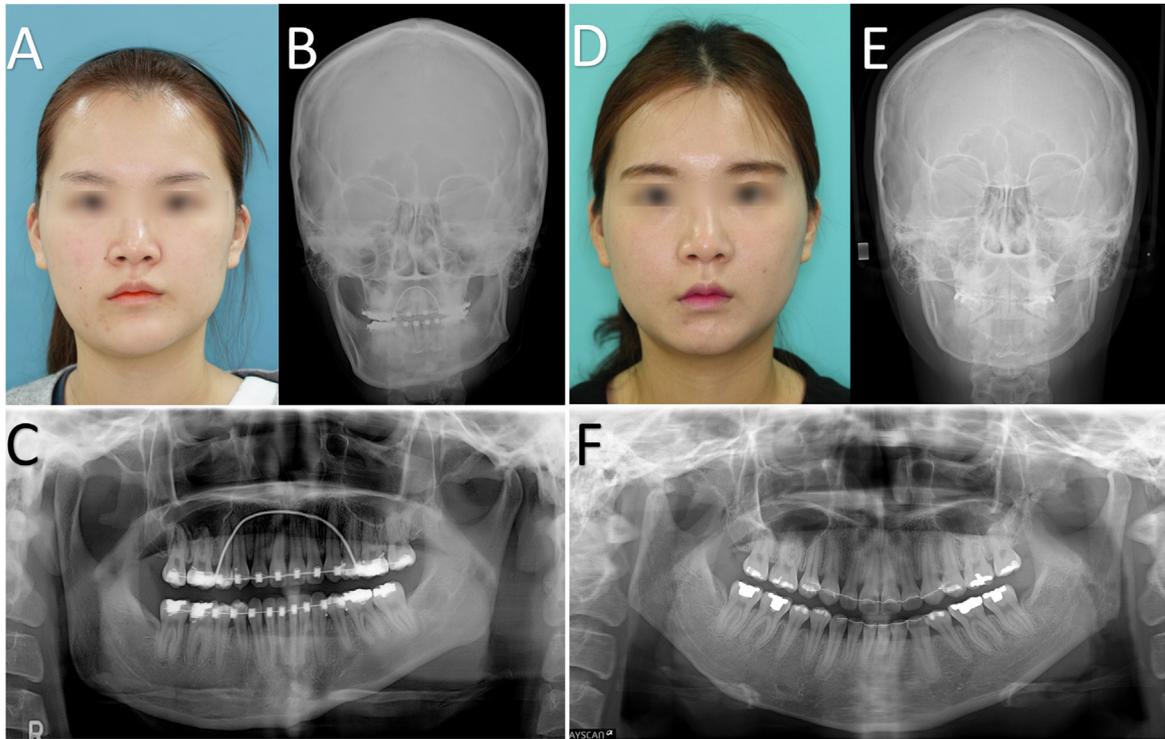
Long-term follow-up of a hemimandibular hyperplasia case (patient 18). Images obtained preoperatively: (A) frontal photograph, (B) posteroanterior radiograph, and (C) panoramic radiograph. Images obtained at 4 years after condylectomy with simultaneous orthognathic surgery and mandibuloplasty: (D) frontal photograph, (E) posteroanterior radiograph, and (F) panoramic radiograph.
